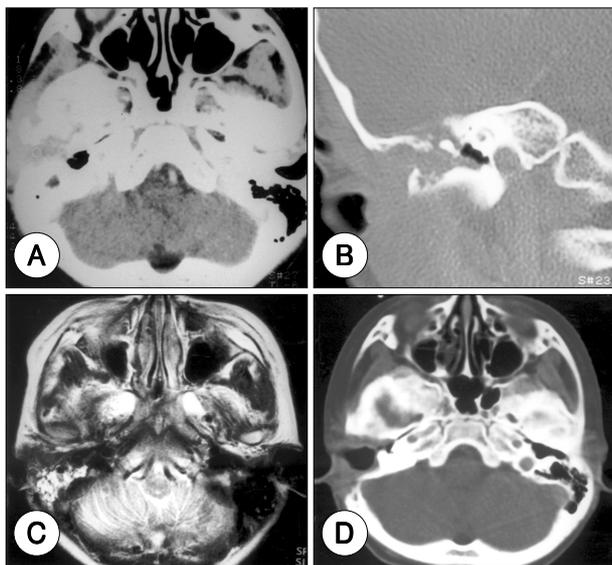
Case 2. A and B : Axial enhanced and bone window coronal computed tomography(CT) scans showing osteolytic defect in right temporomastoid region with large, homogeneous, well enhancing soft tissue mass. Note the erosion of the ossicular chain and the floor of middle cranial fossa. C : Preoperative axial T2-weighted magnetic resonance image showing mainly hyperintense lesion filling the right mastoid antrum and air cells. D : Postoperative axial CT scan demonstrating no residual or recurrent mass.
